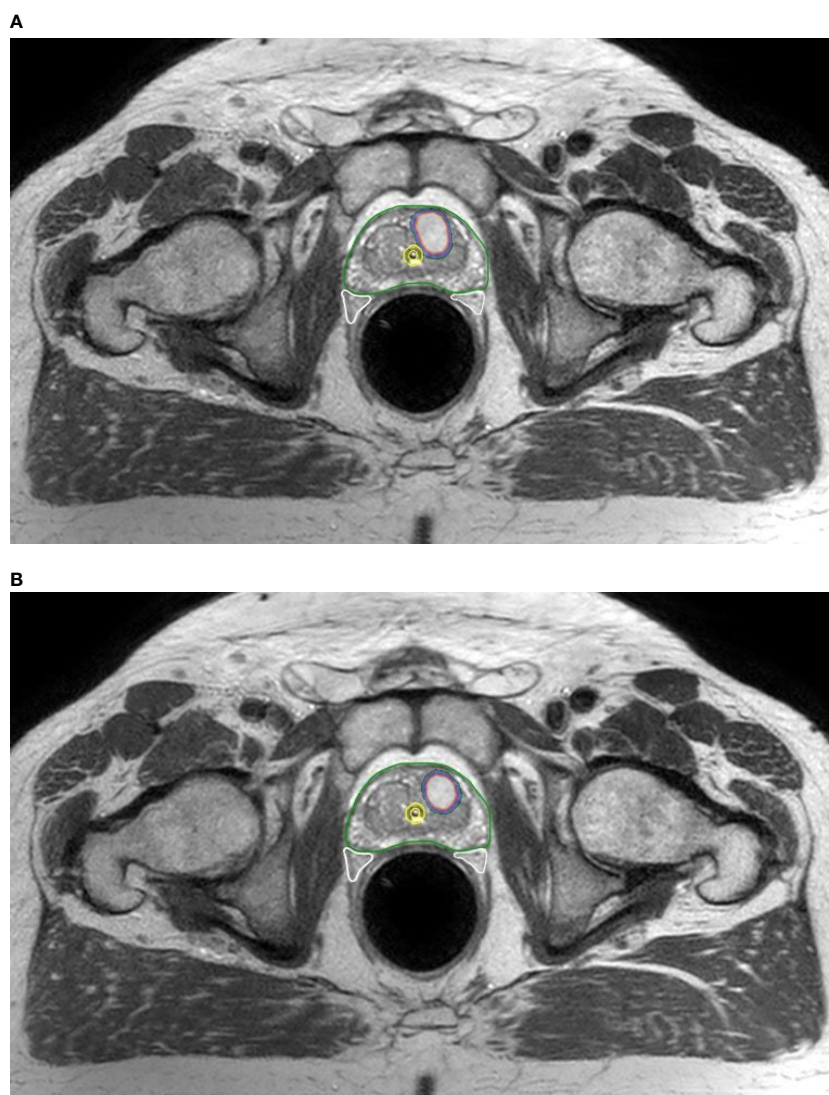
$^{68}\text{PSMA}$ -detected relapse in a patient who received 5-fraction SABR. (A) Fused $^{68}\text{PSMA}$ -PET/CT and planning MRI show pretreatment location of $^{68}\text{PSMA}$ -detected dominant intraprostatic lesion (DIL) encompassed within the CTV and receiving the full 45 Gy prescription dose; (B) fused $^{68}\text{PSMA}$ -PET/CT acquired at the occurrence of biochemical relapse with the planning MRI scan shows persistence/recurrence of the DIL at the initial site.
